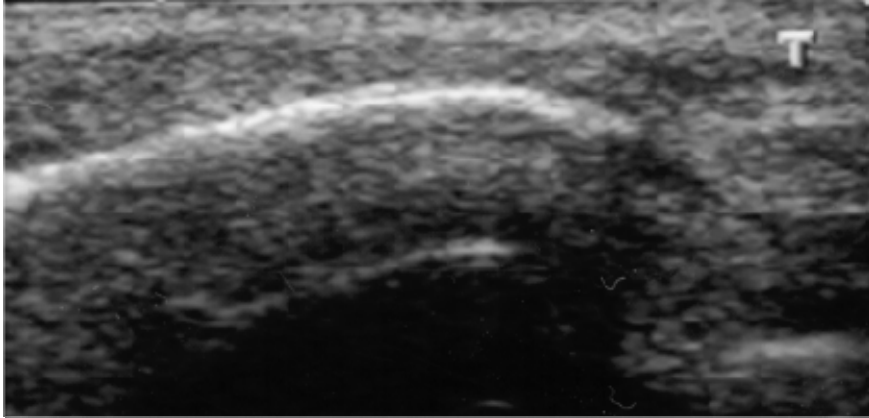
Normal sonographic finding of the lateral nasal wall in a 27-year-old man after nasal trauma
